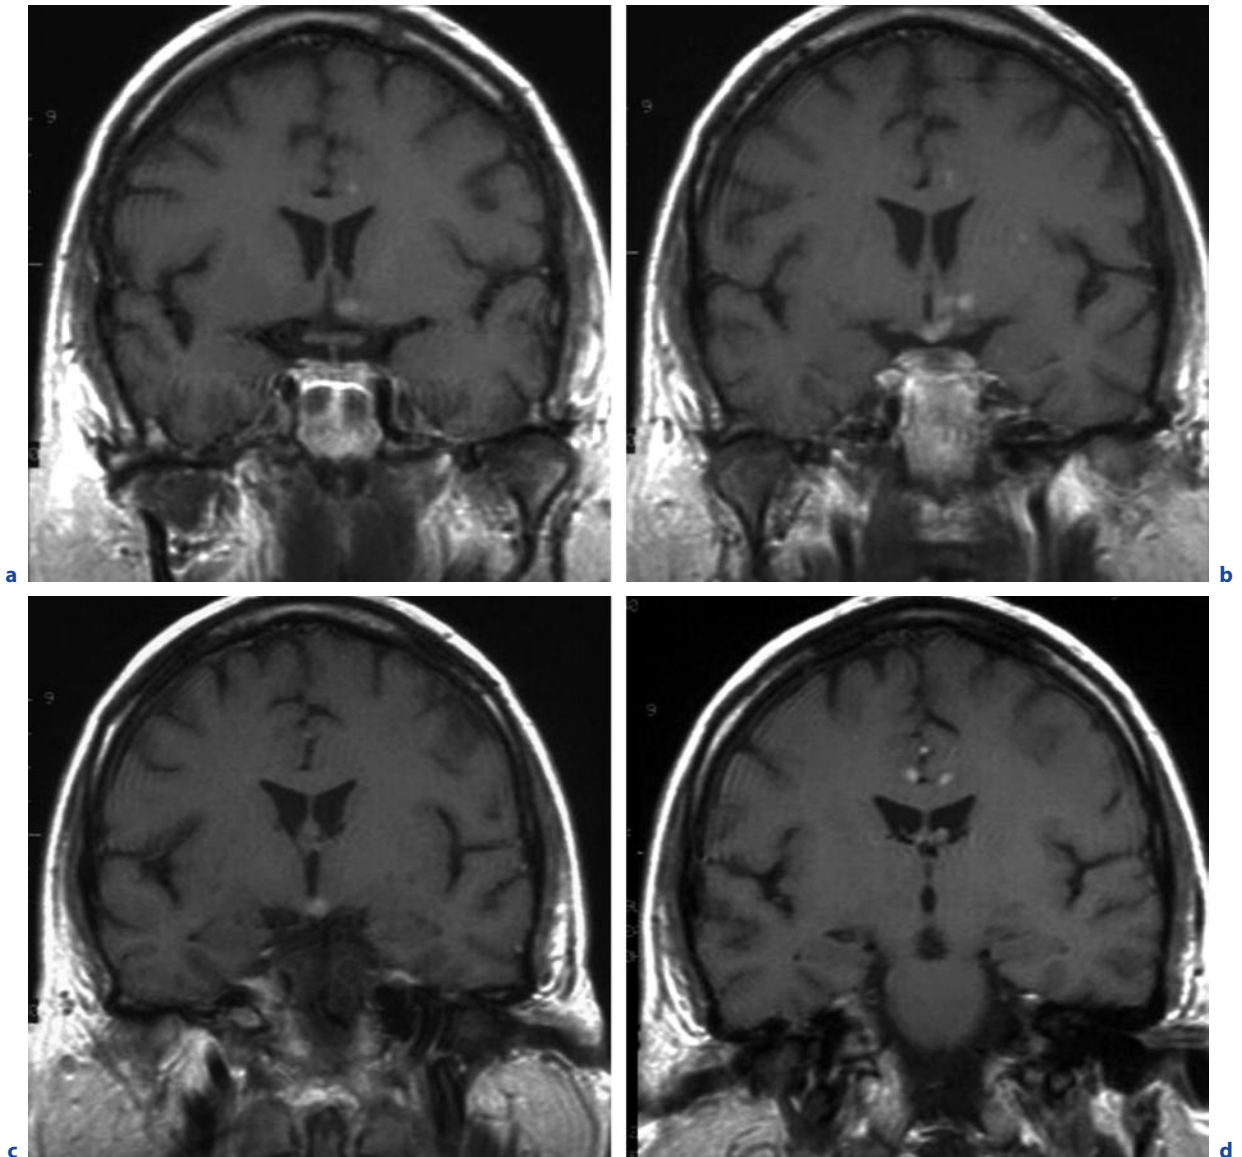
Whipple’s disease. a–d Coronal T1-weighted images after contrast administration. Multiple enhancing lesions in the hypothalamus, and the parasagittal frontal cortex (cingulate gyrus) above the corpus callosum
